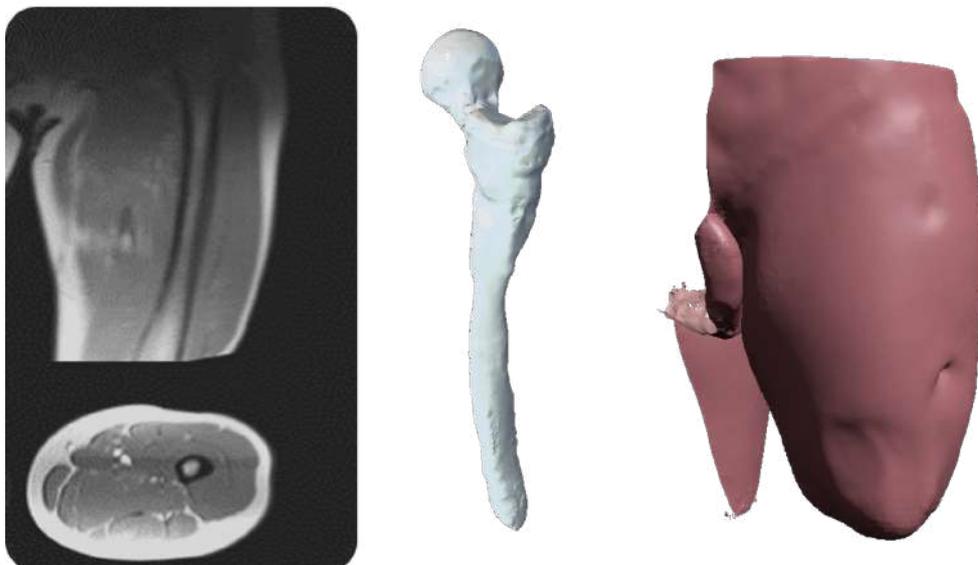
Automatic 3D reconstruction from MRI volume of an above amputated lower limb.
